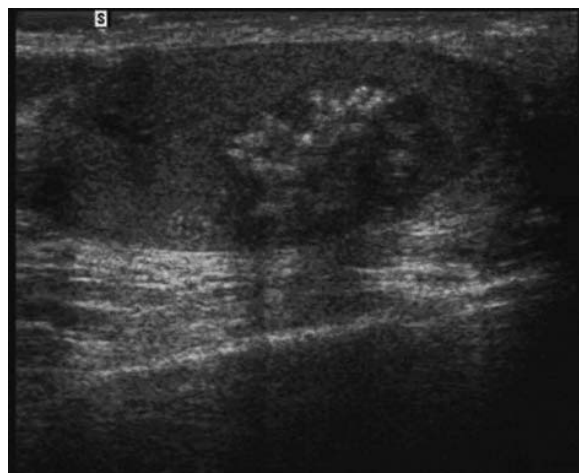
Longitudinal view by scrotal ultrasonography demonstrating a hypoechoic mass with calcific shadowing.
